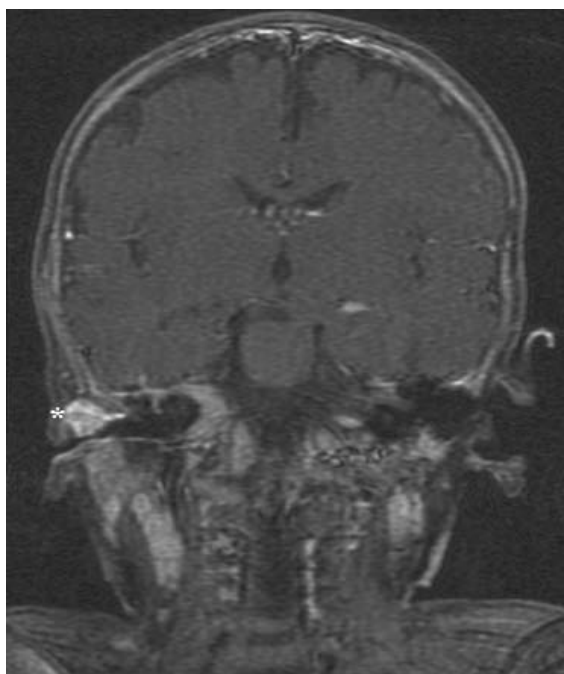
Coronal cranial magnetic resonance imaging of the patient shows a hyperintense lesion (*) in the superior wall of the right external auditory canal.
